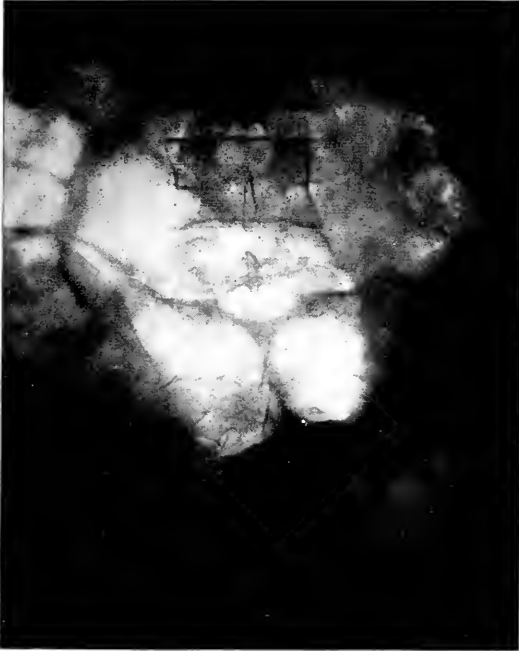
ROENTGENOGRAM. METASTASIS OF CARCINOMA OF THE FIFTH LUMBAR VERTEBRA.
